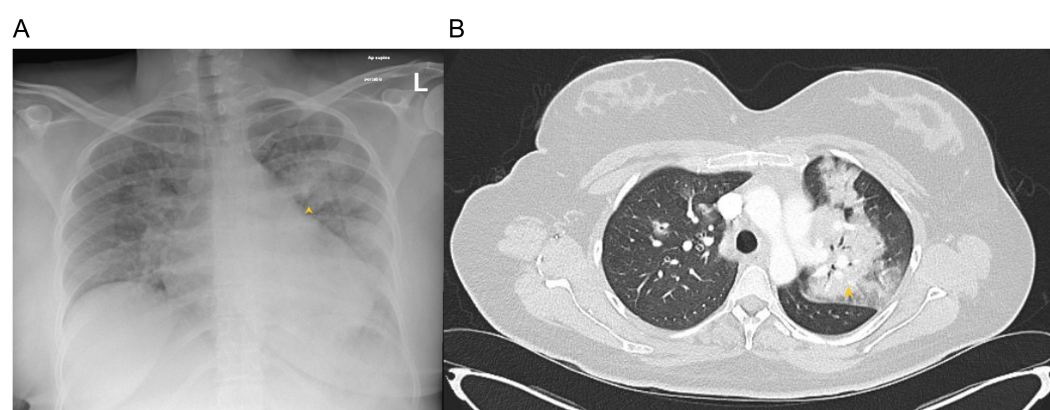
Examples of radiological changes in influenza pneumonia. (A) Chest X-ray (CXR) showing consolidation in a patient admitted with influenza (yellow arrow). (B) Corresponding computed tomography (CT) showing consolidation in the same patient (yellow arrow)—source author. L, left.
